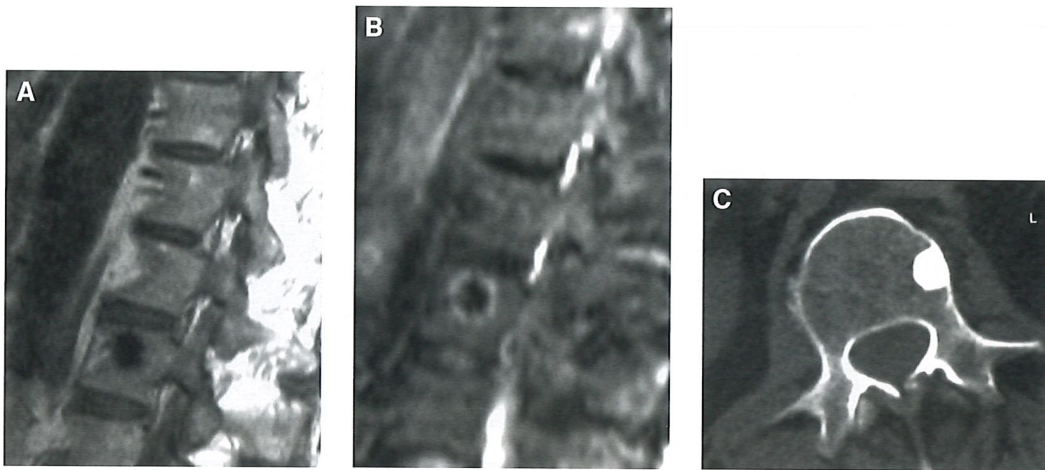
Atypical enostosis. (A) Sagittal T1-weighted image of the lumbar spine shows an area of decreased signal intensity. (B) On the sagittal fat-saturated intermediate-weighted FSE image, the lesion shows a central area of low signal intensity and a peripheral rim of high signal intensity. (C) Axial CT image shows a vertebral enostosis. Bone scintigraphy (not shown) was normal. Rarely, vertebral enostosis may show a peripheral rim of high signal intensity on fat-saturated intermediate-weighted FSE images.
